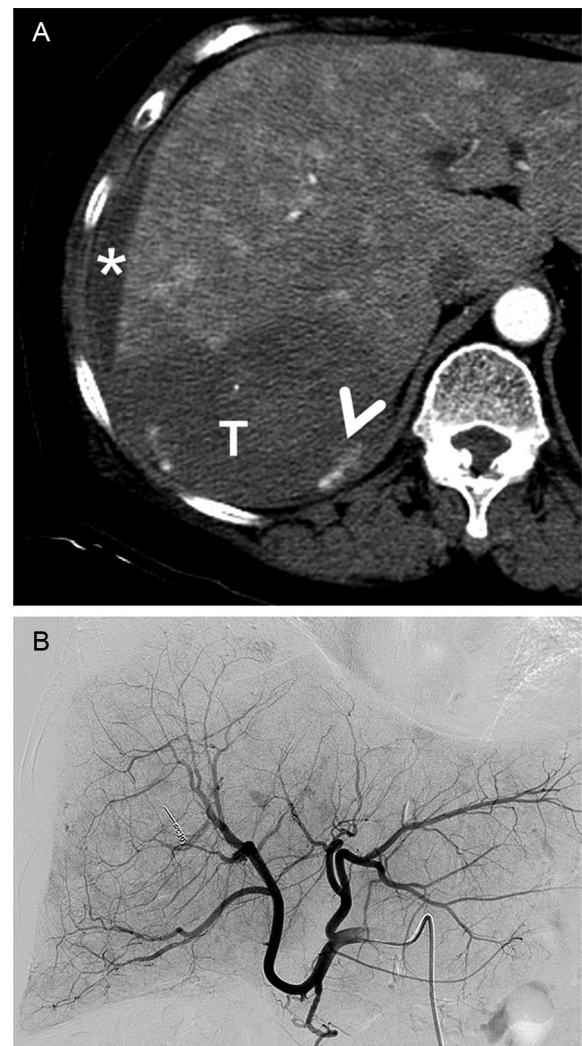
(A) Second bleeding episode: two-phase contrast computed tomography showing a hypodense hepatic tumor with hemoperitoneum and extravasation. (B) Second bleeding episode: angiogram showing previous transarterial embolization coil and no extravasation. Arrow head = extravasation; Asterisk = hemoperitoneum; T = tumor.
